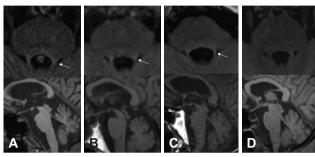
Conventional fluid-attenuated inversion recovery MRI at the pontine level with superior cerebellar peduncle (SCP) fibers. Patients with progressive supranuclear palsy with Richardson's syndrome showed high signals in the SCP on the axial view and atrophy of the SCP on the sagittal view (arrows) (A-C). Patients with Parkinson's disease (D) showed no changes in the signal and atrophy of the SCP.
